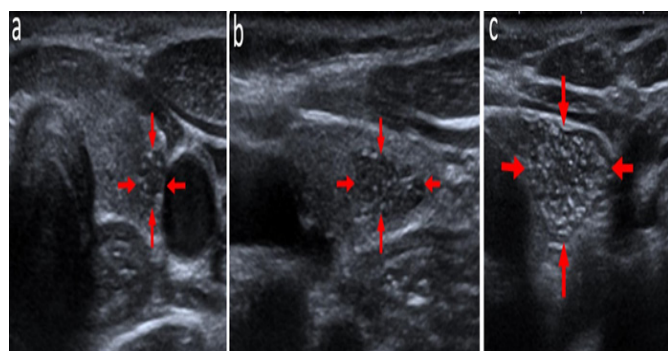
US appearance of IET in a 5-year-old boy. The lesion is hypoechoic compared with the surrounding thyroid parenchyma and contains punctate echogenic foci, showing a characteristic ultrasonographic similarity to normal thymic tissue (marked with red arrows).
